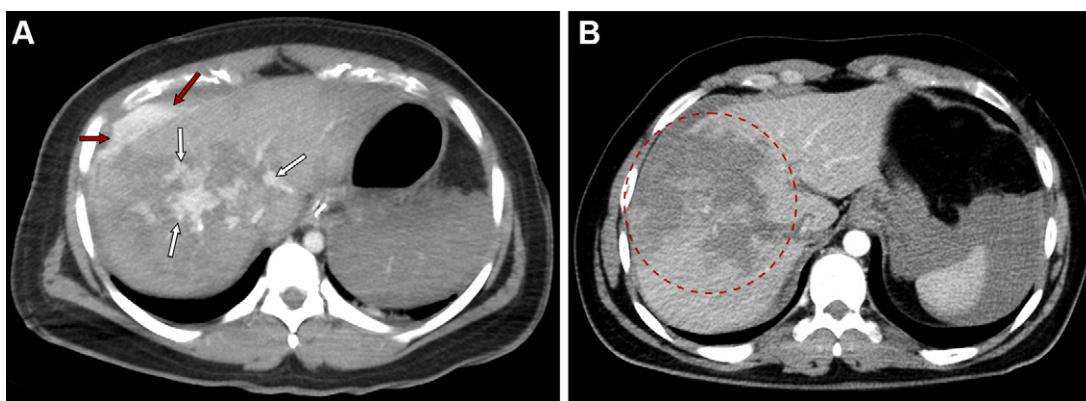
Grade IV liver injuries according to the revised 2018 AAST-OIS. (A) Axial contrast-enhanced CT image in a 46-year-old man after a pedestrian-versus-motor-vehicle collision shows major disruption of the right hepatic lobe, with active contrast material extravasation both within the liver parenchyma (white arrows) and extending into the peritoneum (red arrows). Inclusion of vascular injuries with active bleeding extending beyond the liver parenchyma into the peritoneum was one of the major changes included in the AAST-OIS revision. An axial cine clip of this patient is shown in Movie 9. (B) Axial contrast-enhanced CT image in a 21-year-old man after a fall off a train platform while intoxicated shows approximately 50% disruption of the right hepatic lobe (red oval). Hemoperitoneum is present, with fluid in the perihepatic and perisplenic regions. According to the AAST-OIS 2018 revision, the Couinaud segments are no longer used for quantifying parenchymal disruption.
